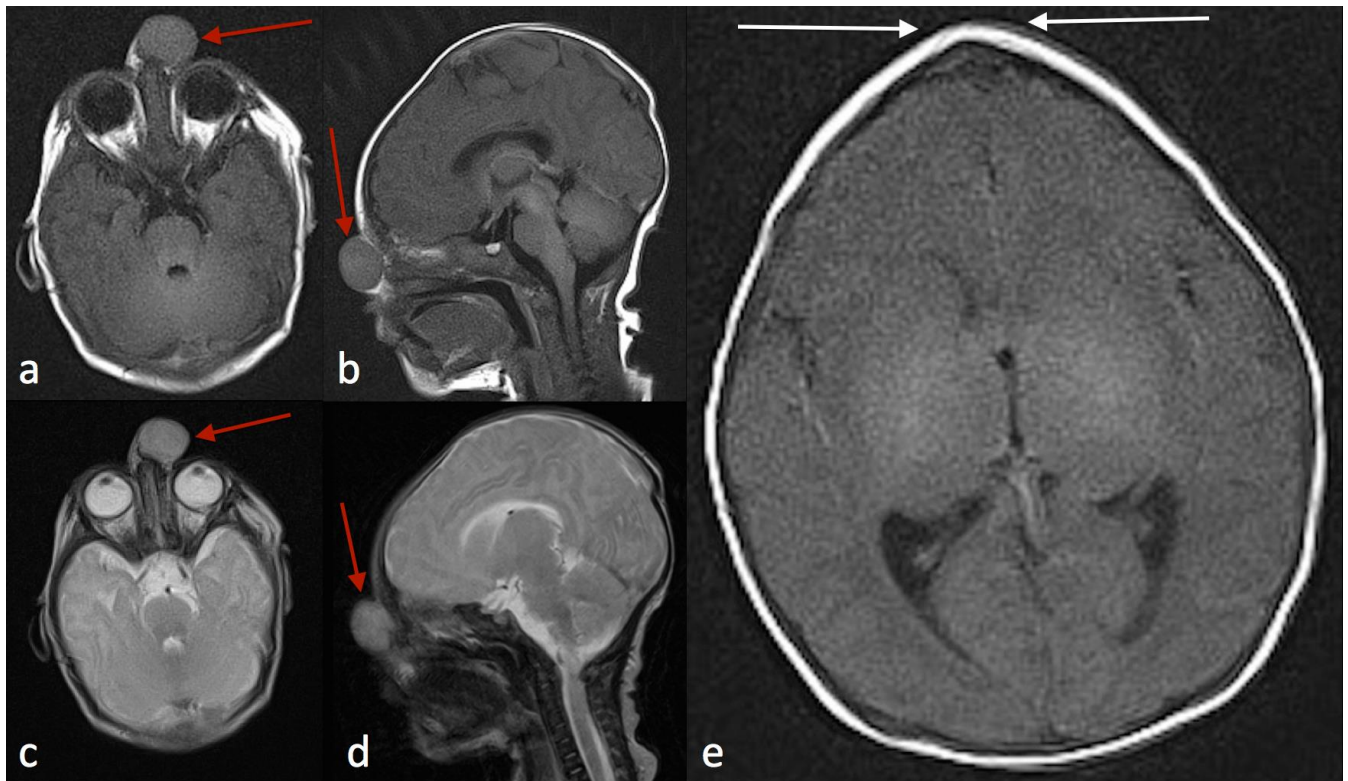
Two-day-old female neonate with nasal glioma. Axial and midline sagittal T1 Blade MR images (a & b), axial T2 Blade MR image (c), and sagittal T2 tse image (d) demonstrate a 1.8 x 1.5 x 2.0 cm left paramidline frontonasal mass immediately superior to the nasal bridge that is isointense to brain parenchyma on all sequences. The lack of connection to the intracranial structures differentiates this nasal glioma from a frontonasal encephalocele. An additional axial T1 Blade image (e) demonstrates trigonocephaly (white arrows). Technique: 1.5 T magnet strength, Avanto MR, Siemens, Germany, axial T1 blade sequence 1800 TR, 55 TE, 4.0 mm slice thickness; sagittal T1 blade sequence 1940 TR, 55 TE, 4.0 mm slice thickness; axial T2 blade sequence 4000 TR, 99 TE, 4.0 mm thickness; sagittal T2 weighted image 5120 TR, 115 TE, 4.0 mm slice thickness.
